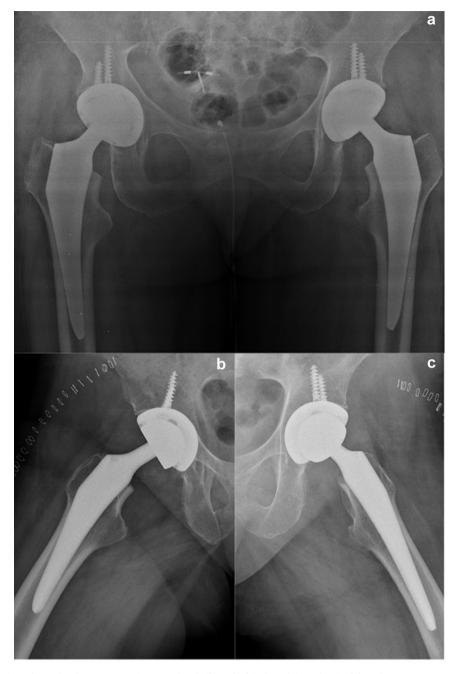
Immediate postoperative radiographs. The anteroposterior view (a), right (b), and left (c) lateral views showing bilateral one-stage uncemented THA with a 36-mm metal-on-polyethylene bearing surface.
